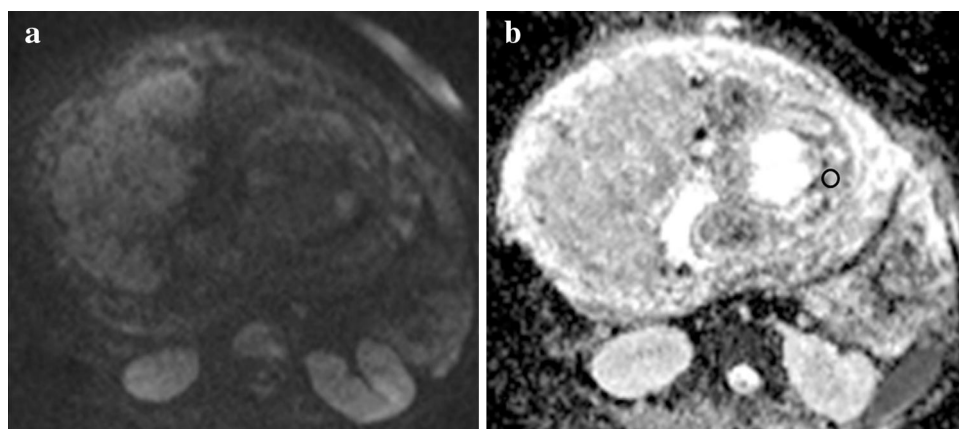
Diffusion-weighted magnetic resonance imaging (DW-MRI) with b = 700 s/mm² (a) and ADC map (b) demonstrated decreased cortical and medullary ADC values (ADC = 0.98 × 10⁻³ mm²/s) (O in b) suggesting failure of the hypoplastic left kidney
